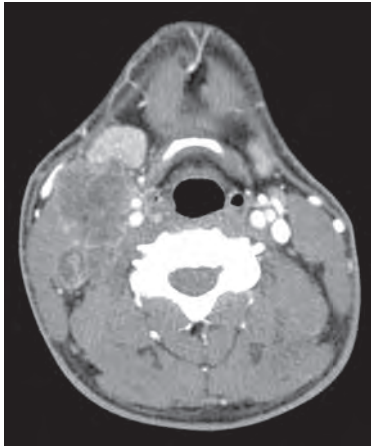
An enhanced axial computed tomography scan showing a heterogeneous mass in the right submandibular region with central necrosis
